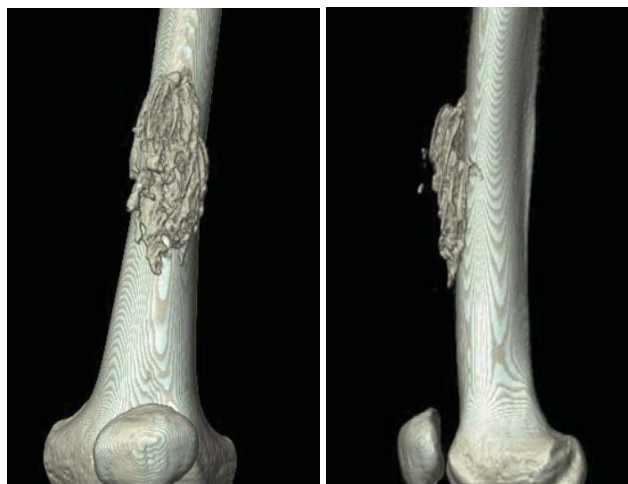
Three-dimensional CT scans provided detailed images of flocculent calcifications, as an immature calcified mass.
